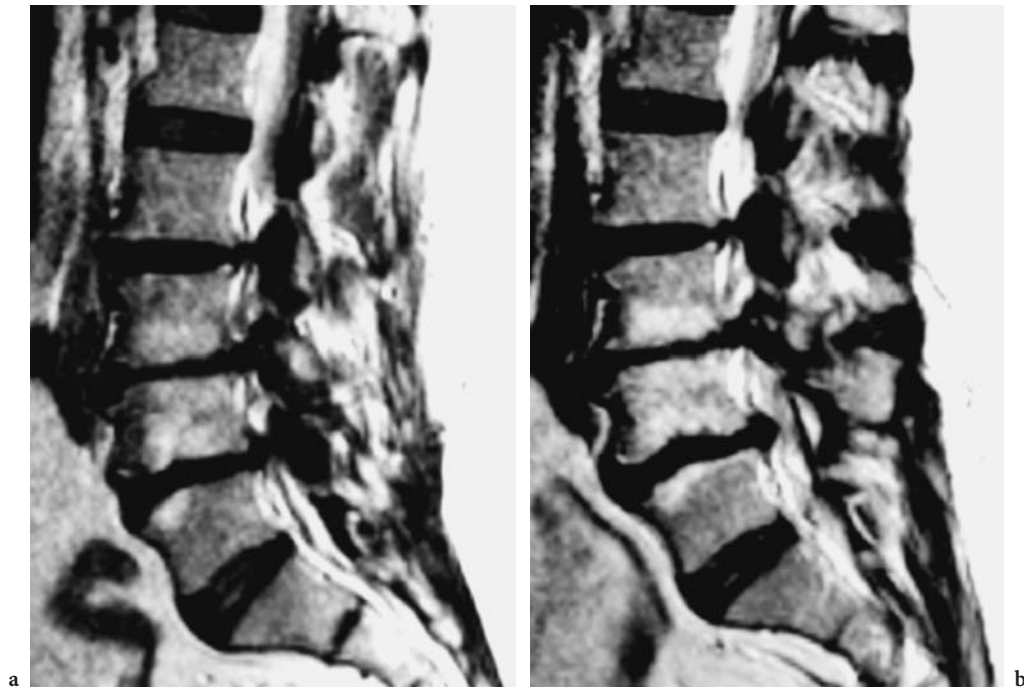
Paradoxical motion during loading. a Supine-unloaded MRI: multiple discopatias with disc protrusion in L2–L3, L3–L4, L4–L5. Yellow ligaments are thickened with central stenosis at the same levels. b During AL-MRI: paradoxical motion of L5. All disc protrusions increase, in particular at L4–L5
